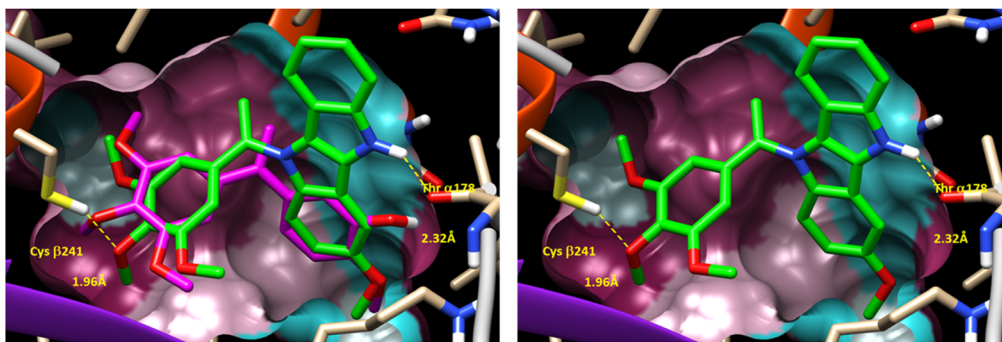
(Left) Putative binding mode of DINI derivative 6g (green color) within colchicine binding site of tubulin X-ray structure (accession code 6H9B) (left) with previously reported binding mode of reference compound isoCA-4 in overlay (magenta color). (Right) Same figure (without isoCA-4 reference binding mode).
